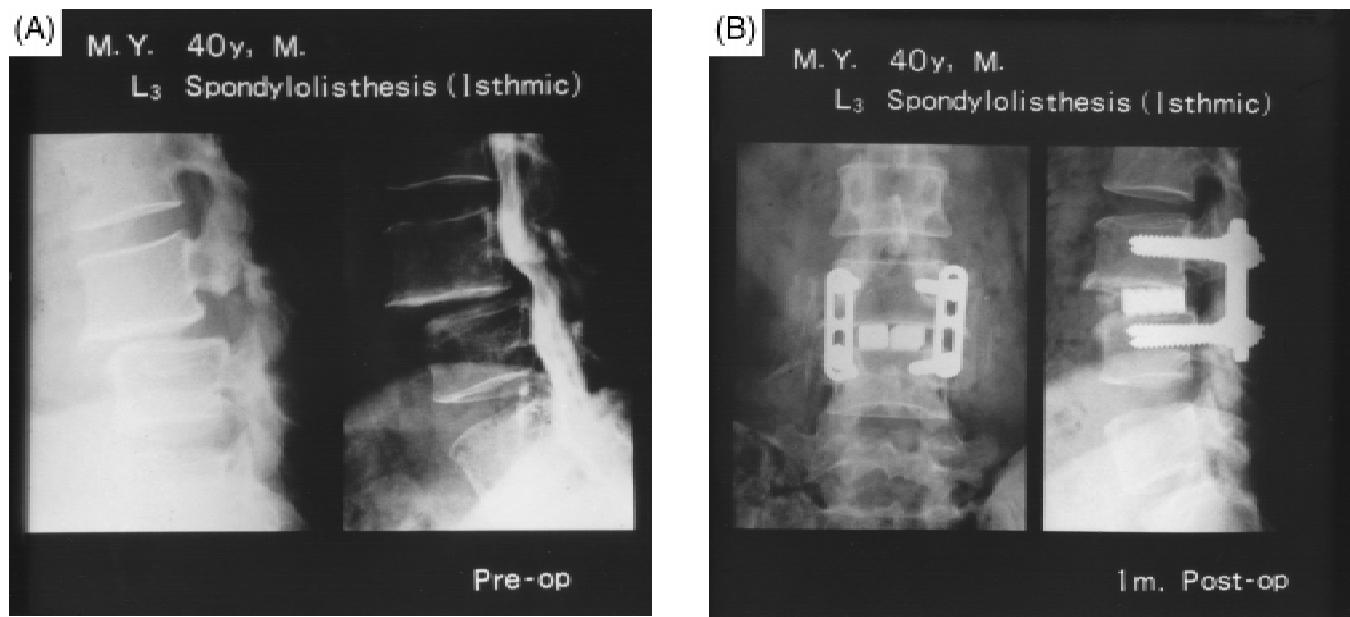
Case of spondylolisthesis with symptoms of lumbar canal stenosis: (A) preoperative lateral X-ray view (left) and lateral myelogram (right) and (B) postoperative anterior-posterior and lateral X-ray views using bioactive glass-ceramic A/W laminoplasty spacer. (Photo courtesy of Professor T. Yamamuro.)
